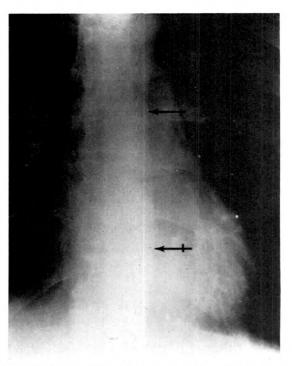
A normal posteroanterior erect chest roentgenogram. The aorta (++) is in normal position. The left paravertebral line is not seen.
